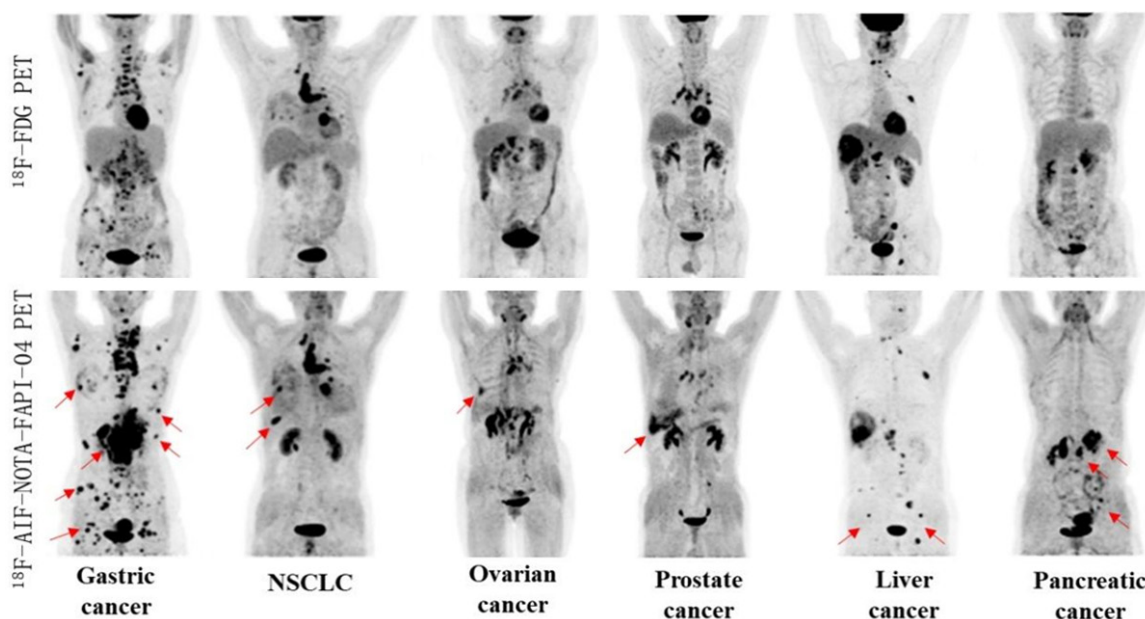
Detection results of metastatic tumor by different methods. Images of 6 patients undergoing [¹⁸F]-FDG and [¹⁸F]-AIF-NOTA-FAPI-04 PET/CT. The number of metastases in FAPI imaging was significantly higher than that in FDG images.
